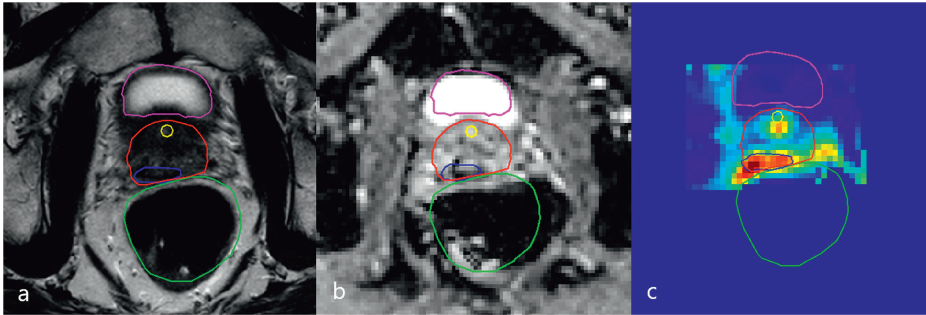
Diagnostic 3T mp-MRI revealing first recurrence lesion.
